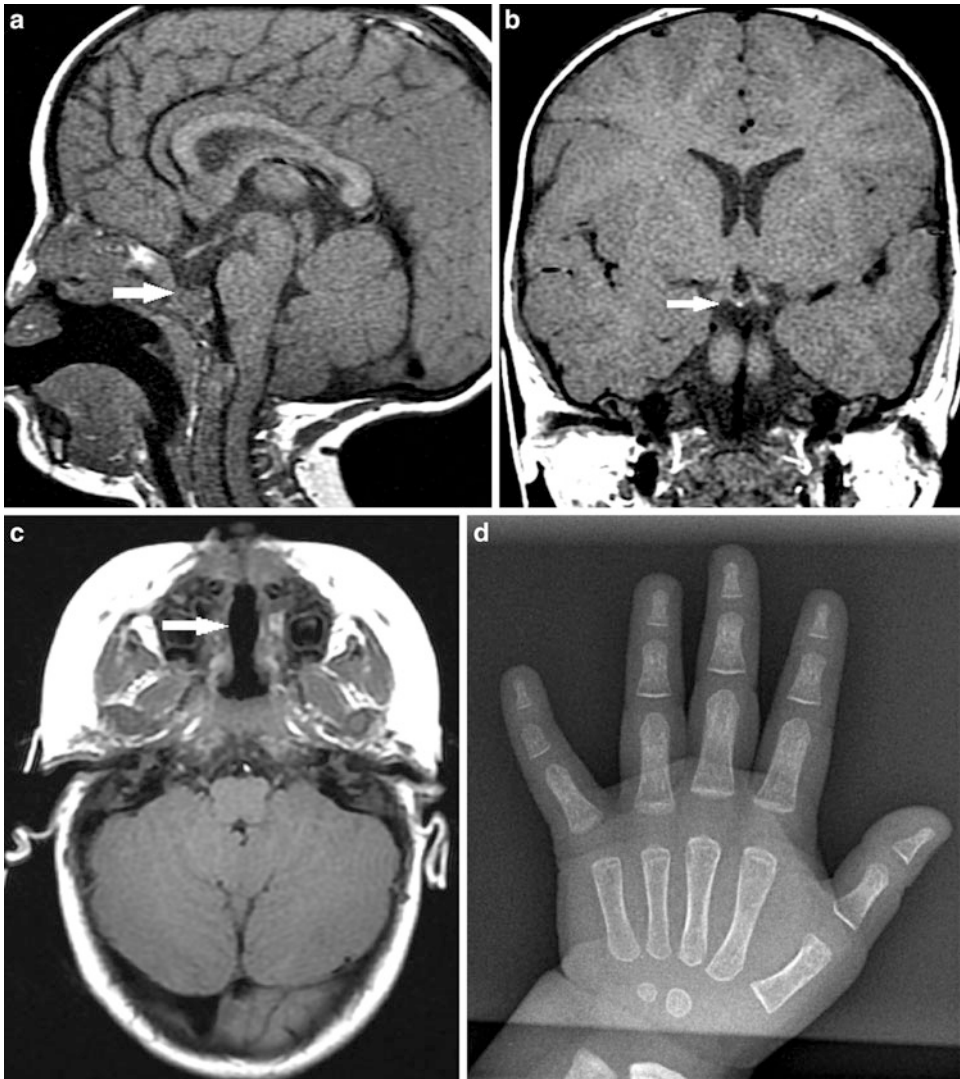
(a–d) A 3-years-old girl was diagnosed with isolated growth hormone deficiency. She initially presented for small stature and abnormal MRI of her pituitary gland. Her height was 66.9 cm, which is less than the 3rd percentile. The weight was 7.3 kg, which is less than the 3rd percentile. Blood pressure 88/56, pulse 86. Systemic review was unremarkable for any systemic symptoms. There is decreased level of Insulin-like growth factor 1 (*IGF-1*) and IGF binding protein (*IGFBP-3*). Chromosomal study was reported as normal. MRI images showed
